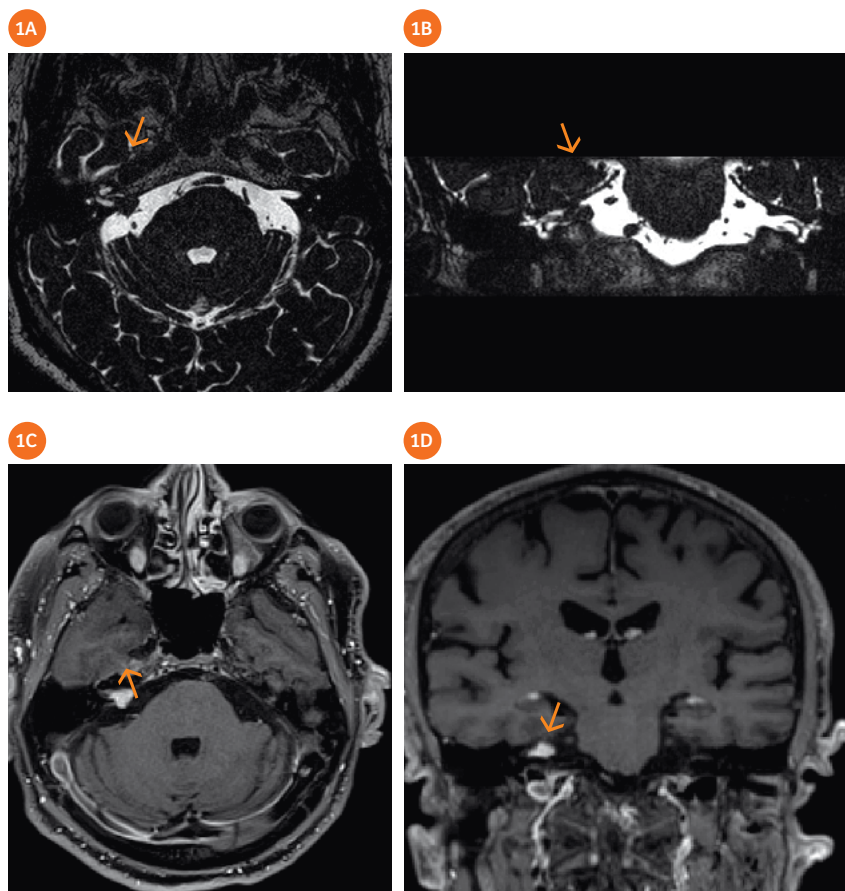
(1A, B) Representation of an acoustic neurinoma (arrow) on the MAGNETOM Avanto^{fit}. T2-weighted SPACE transversal (TR 1200 ms, TE 264 ms, slice thickness 0.6 mm) and reconstructed coronal slice orientations. (1C, D) Contrast-enhanced T1-weighted MPRAGE (TR 1800 ms, TE 2.6 ms, slice thickness 1 mm) with automatically calculated coronal MPR.
